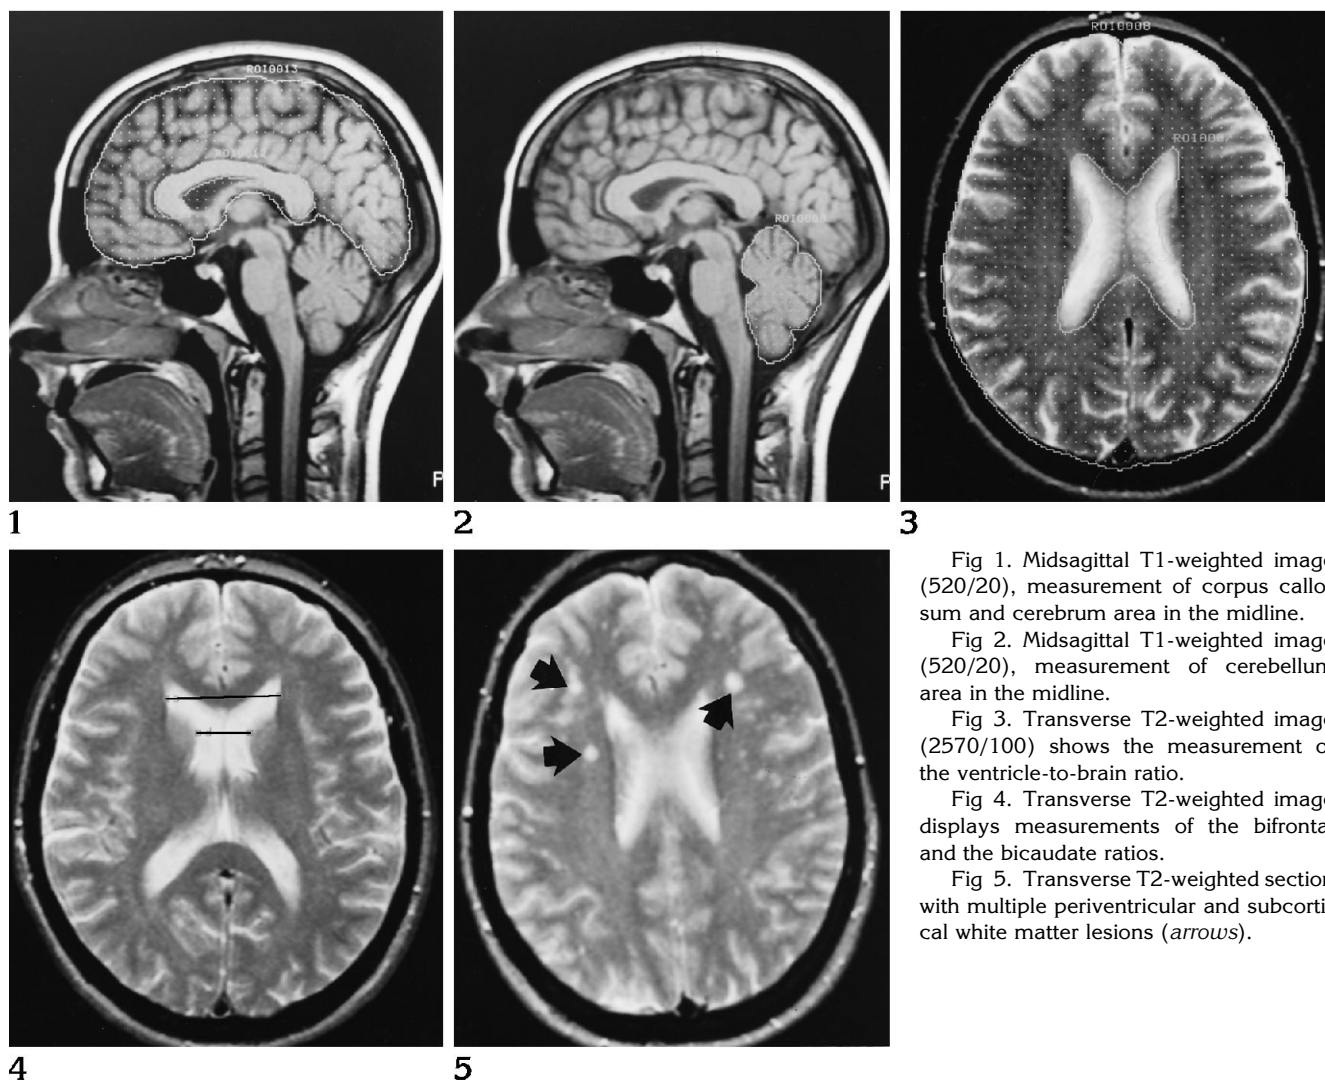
Midsagittal T1-weighted image (520/20), measurement of corpus callosum and cerebrum area in the midline.
